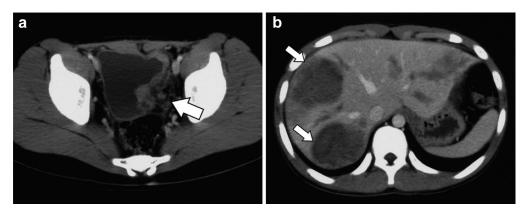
Computed tomography images of the patient. a: Image of the patient's bladder, displaying thickening of the bladder wall (arrow). b: Image of the patient's liver, displaying large multiple masses (arrows).
